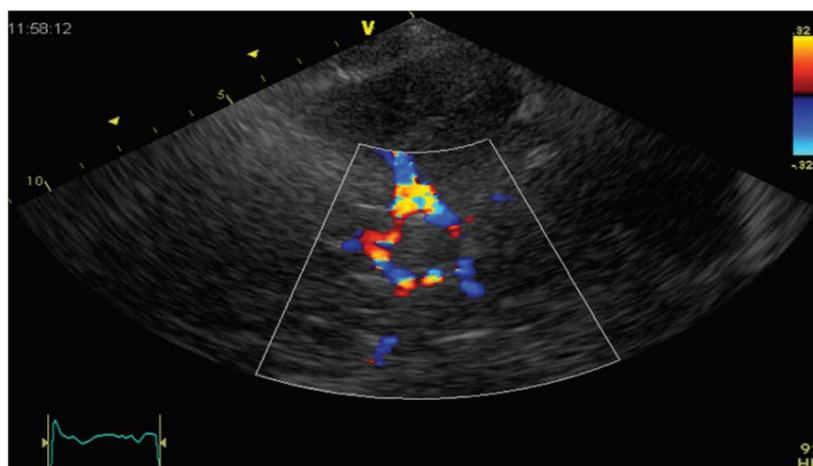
Left panel: Transmission of ultrasound beam through skull using Pulsed Doppler sectorial probe with a 2.0-3.5 MHz emission frequency. Probe is positioned on temporal window. Right panel = Circle of Willis
